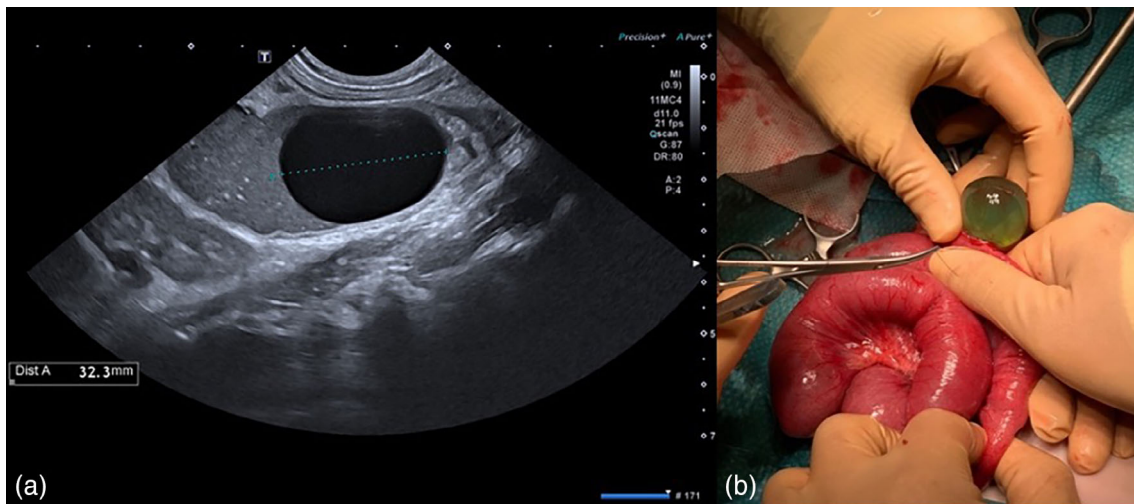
(a) Ultrasonography: jejunoileal loops show distension up to 25 mm containing round anechoic ball formation. (b) After enterotomy, the intraluminal foreign bodies were pushed to the most distal sphere.
